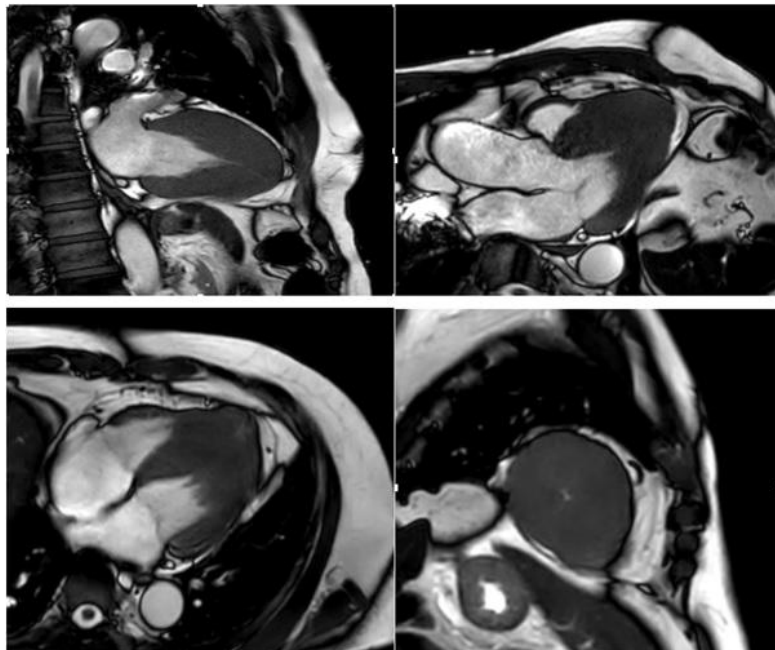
Cardiac MRI. Functional cine images show hypertrophic in the level of mid-apical with a maximal wall thickness of 22 mm during the diastolic phase. Systolic mid-apical obliteration, no apical aneurysm, normal systolic function (EF 62%), LV mass 219 grams, fibrosis mass 7.4 grams, no SAM, normal pericardium
